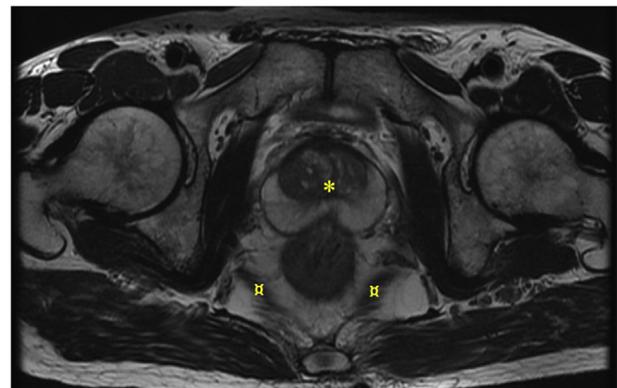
Main structures at point A on transverse section of MRI. the Axial T2WI image at the level of point A by using cross-reference technique. The structures anterior and lateral to the rectum at this level are the prostate (*) and the muscles levator ani muscle (□).
